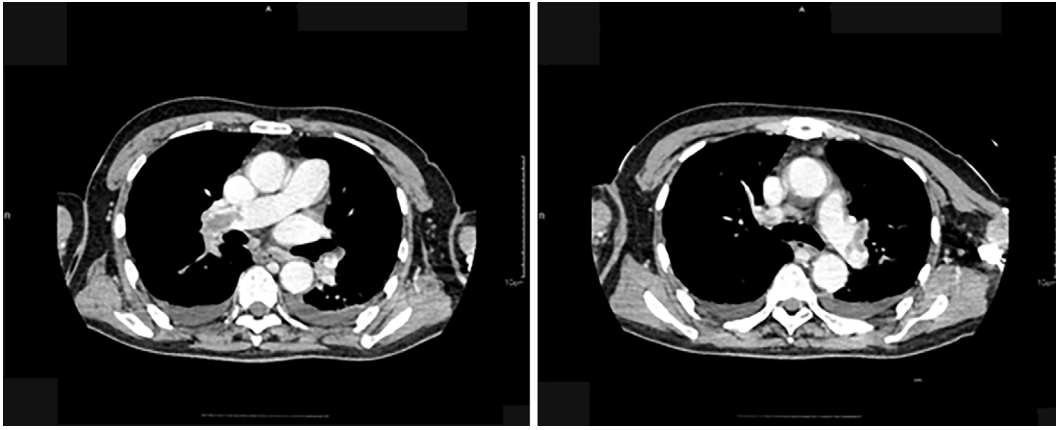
Contrast-enhanced CT showing bilateral pulmonary embolism.
